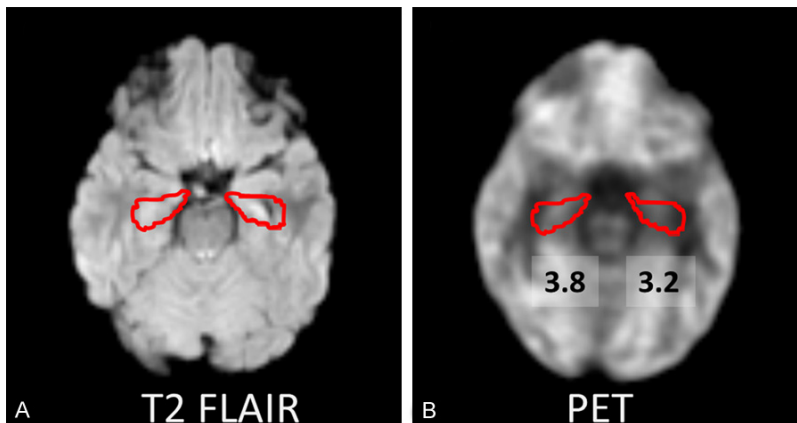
A: A 9-year-old female patient (case 9) with left hippocampal sclerosis shows slightly atrophy of left hippocampus on T2 FLAIR image. B: The co-registered FDG-PET and MRI image shows that left hippocampus has lower SUV (SUV=3.2) than right hippocampus (SUV=3.8).
